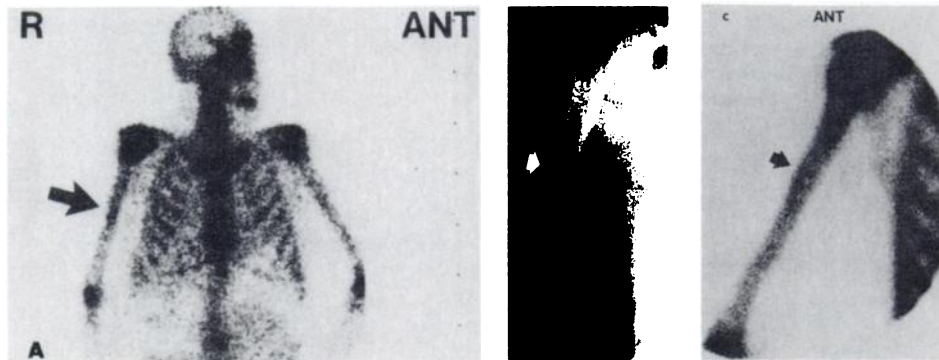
(A) Anterior bone scan demonstrating focally increased radionuclide within right proximal humerus (arrow). (B) Radiograph of right humerus reveals thickened cortex of prominent deltoid tuberosity. (C) Anterior scintiscan of right humerus (internally rotated) shows increased uptake in region of thickened cortex of deltoid tuberosity.
